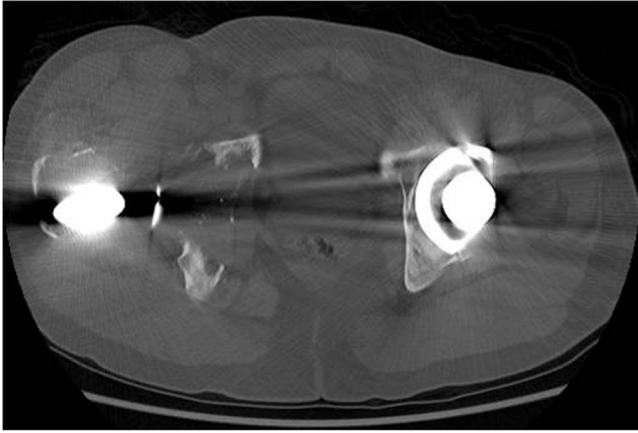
50-year-old man with extensive metallosis. Axial CT of the pelvis in bone windows shows osteolysis of the right acetabulum with foci of small metallic debris. The medial acetabular wall is completely destroyed.
